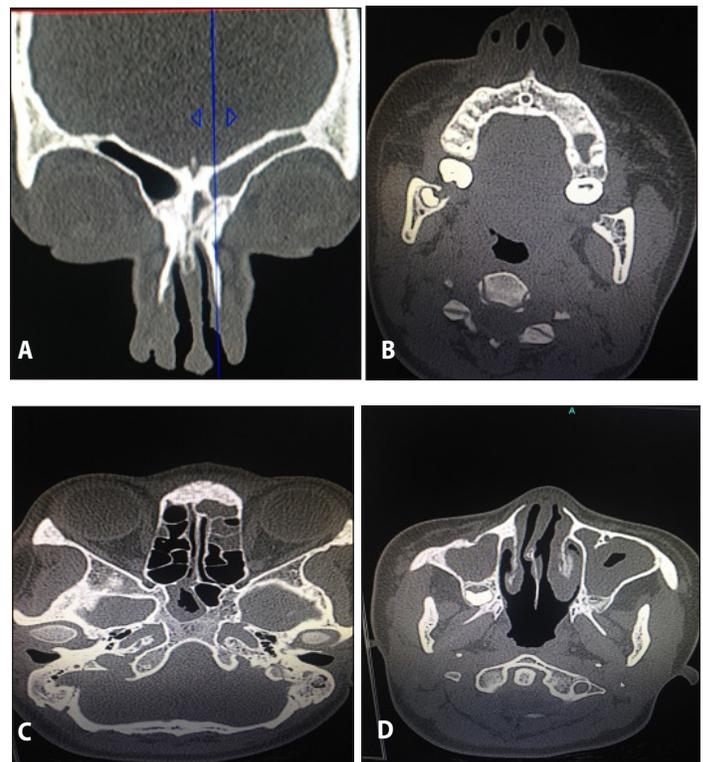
Paranasal Sinus CT scans. A. Coronal and B. Axial cut show a small opening lateral to the right nasal ala that does not communicate with the right nasal cavity. C. and D. Axial cuts reveal opacifications in the left frontal sinus, left anterior ethmoid, both maxillary sinuses and mucosal thickening of the right sphenoid sinus with deviated nasal septum to the right.
